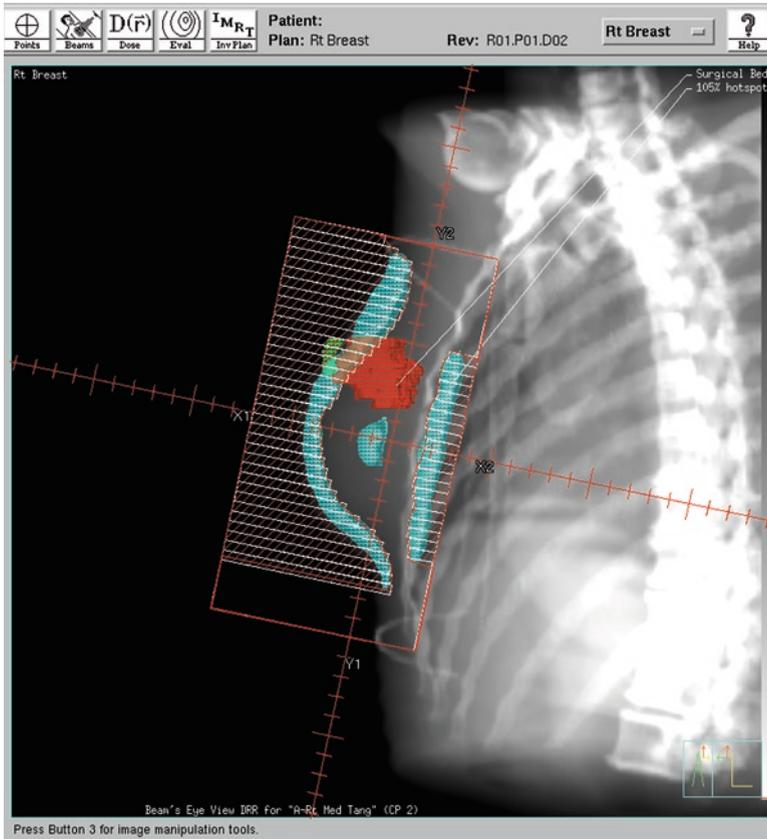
Digitally reconstructed radiograph demonstrating blocking of the 105% dose cloud as part of the step-and-shoot treatment planning for the patient as shown in Fig. 67.2
